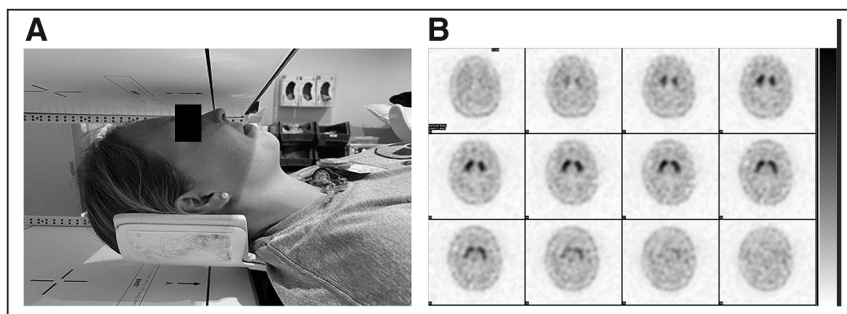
(Left) Correct positioning for brain SPECT scan, with head resting in head-and-neck holder and chin in neutral position. (Right) Axial brain SPECT images showing normal findings and no head tilt.
